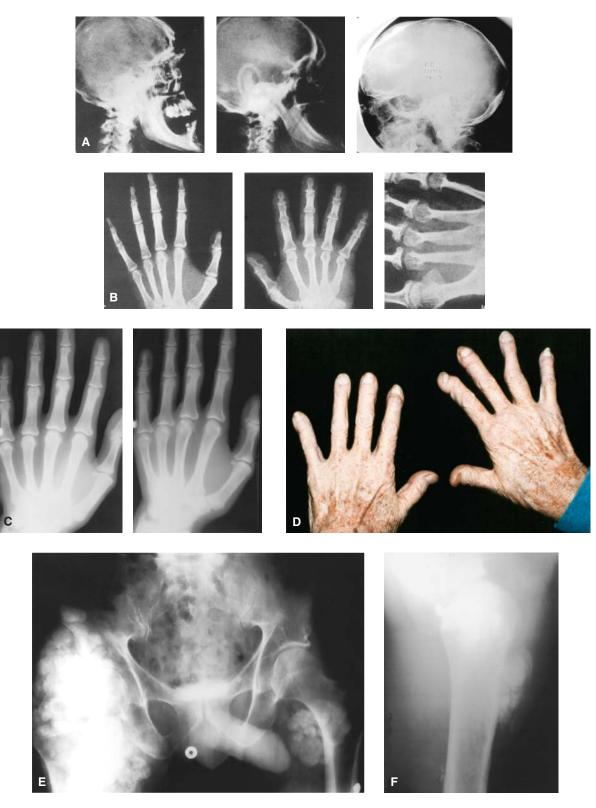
A*, Lytic lesions in the skull. *B*, Radiographic evidence of subperiosteal resorption of phalanges. *C*, Radiographic evidence of subperiosteal resorption best seen on the radial side of the index finger. *D*, Clinical evidence of subperiosteal resorption of the hand. *E*, Fatty brown tumors of long bones. *F*, Fatty brown tumors of long bones.
